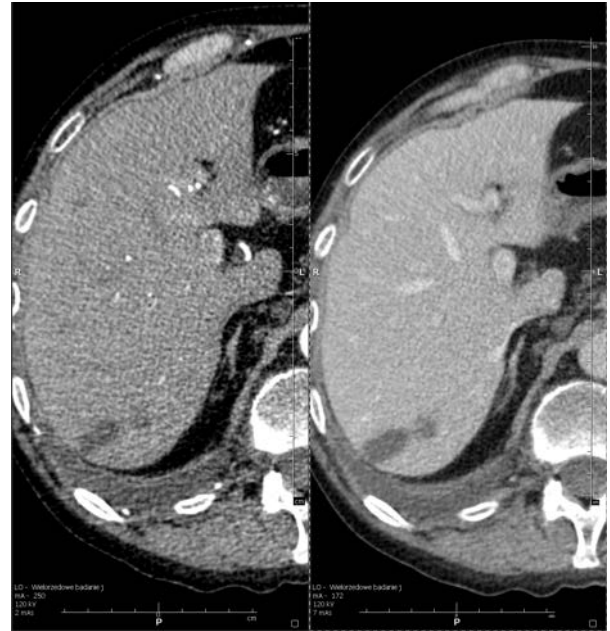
Case 2 — 46 year old man. CT images after administration of contrast. On the left side — the arterial phase, on the right side — the venous phase. The two small, well demarcated nodules in the segment VIII are visible in both phases
